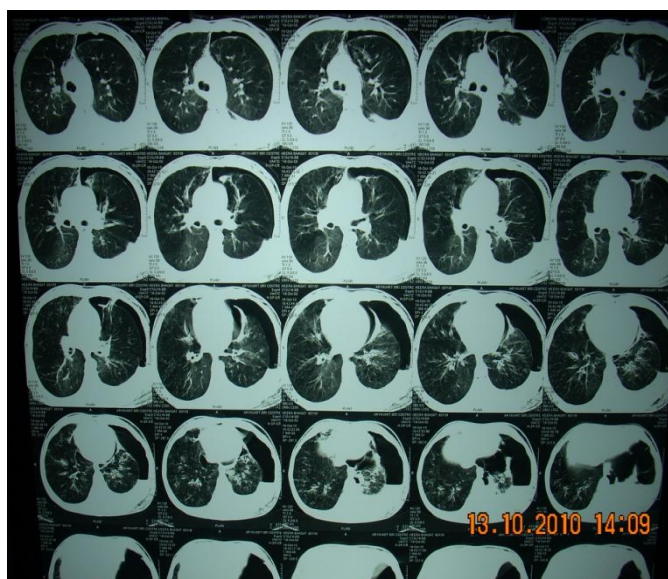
CT scan chest showing haempneumothorax left
